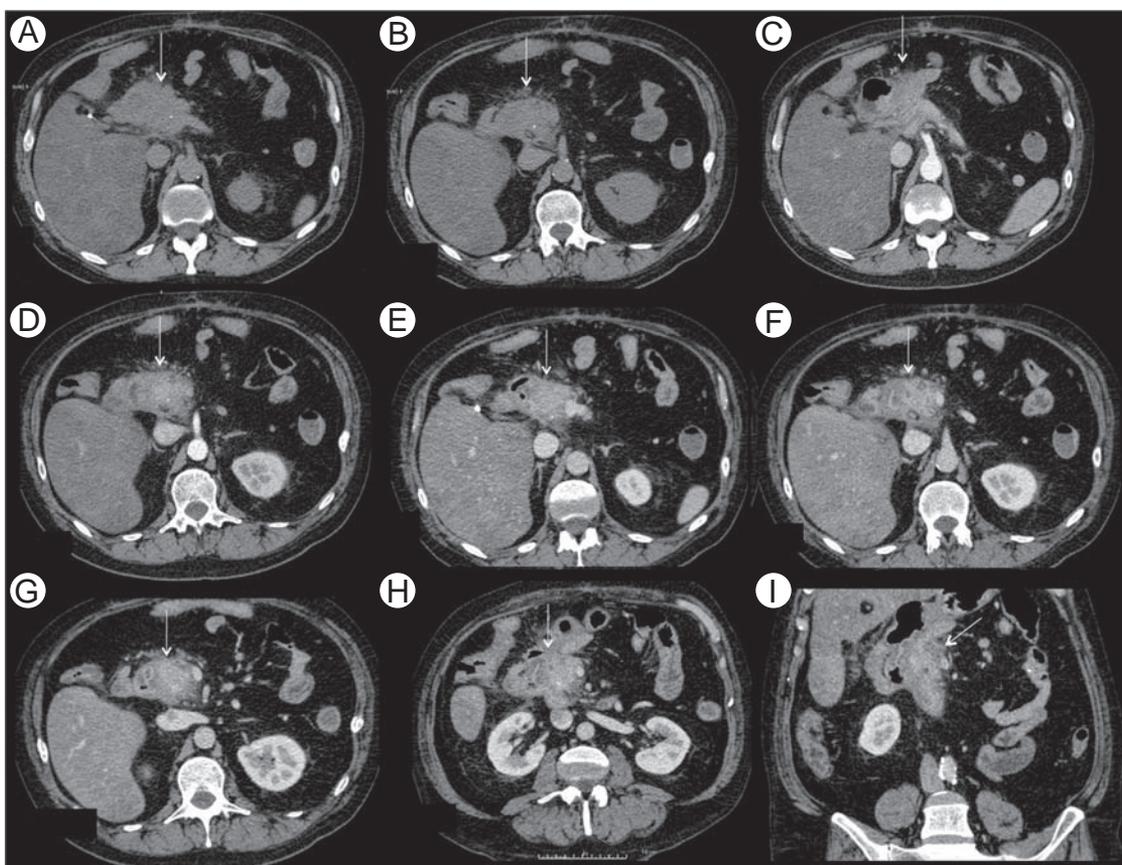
Segmental form of groove pancreatitis in a 44-year-old woman with history of cholecystectomy, presenting with jaundice and abdominal pain. Axial unenhanced (A and B), contrast-enhanced arterial (C and D) and venous (E and F) CT images exhibit enlargement of the pancreatic head with heterogeneous enhancement, small calcifications, and hypoattenuating tissue in pancreaticoduodenal groove (arrows). Thickening and enhancement of duodenal wall also are evident, causing duodenal stenosis. Oblique (G and H) and coronal (I) reformatted CT images in the venous phase better delineate these findings (arrows).
